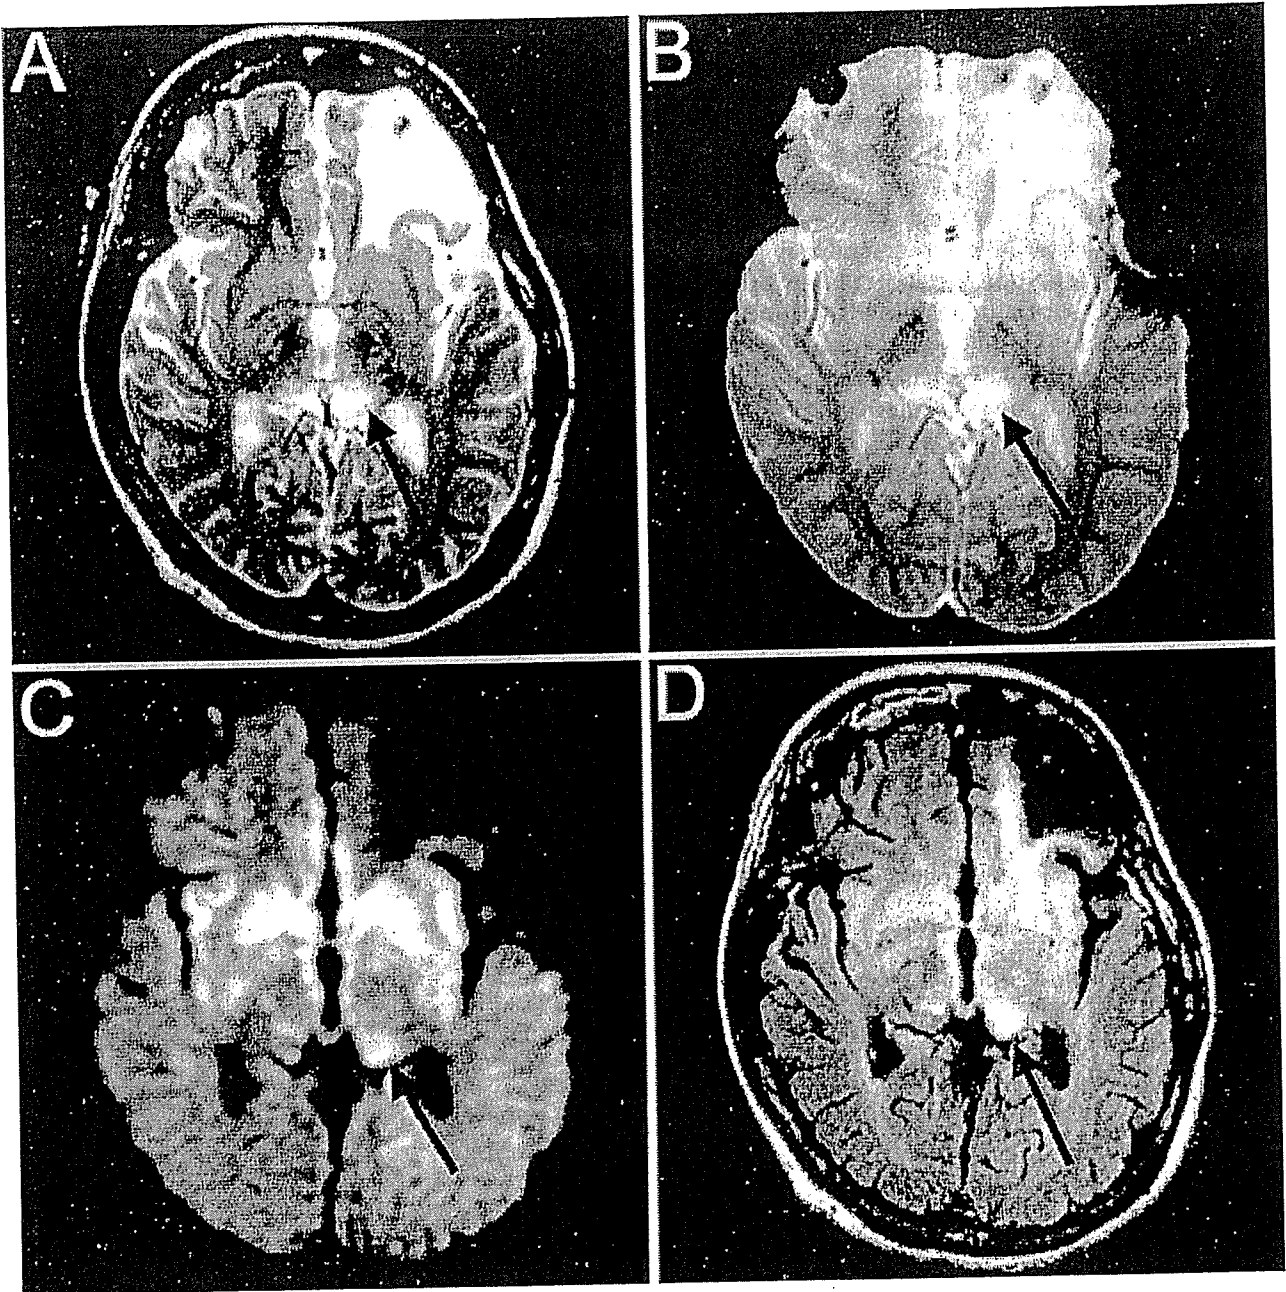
Neuroradiological images. (A) T2-weighted image, (B) proton density-weighted image, (C) diffusion-weighted image, and (D) gadolinium(III)-diethyltriaminepentaacetic acid (Gd-DTPA)-enhanced brain MRI obtained 1 week prior to death. The images reveal hyperintensity in the pulvinar of the thalamus, and is more apparent in the left side (arrows). Images also show intense bilateral signals in the caudate nuclei and putamen.
